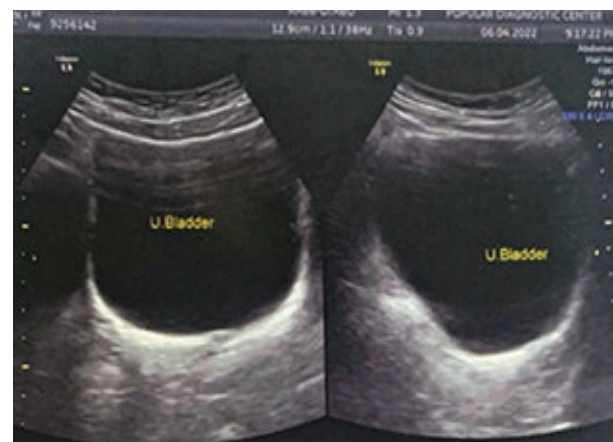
Ultrasound exam: no uterus identified behind the bladder.*
